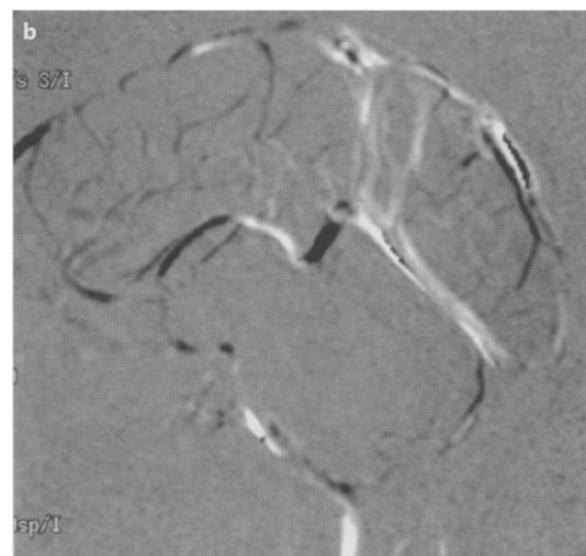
A 2-year-old baby boy with shunted hydrocephalus caused by premature intraventricular hemorrhage. Meningitis and a trapped fourth ventricle. Cine phase contrast sagittal MRI. No flow is seen either in the fourth ventricle or in the aqueduct
